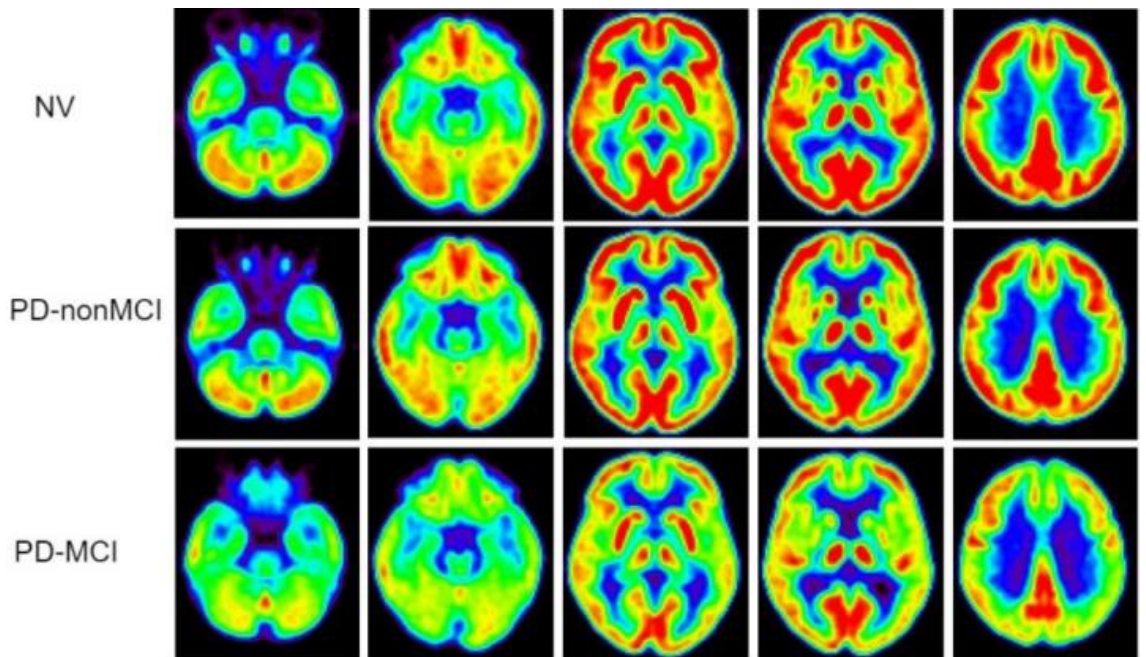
$[^{18}\text{F}]\text{FDG}$ -PET images of healthy controls (NV), PD without Mild Cognitive Impairment (PD-nonMCI) and PD with MCI (PD-MCI). Figure from Eidelberg D. (2011) *Imaging in Parkinson's disease*. Oxford University Press.
